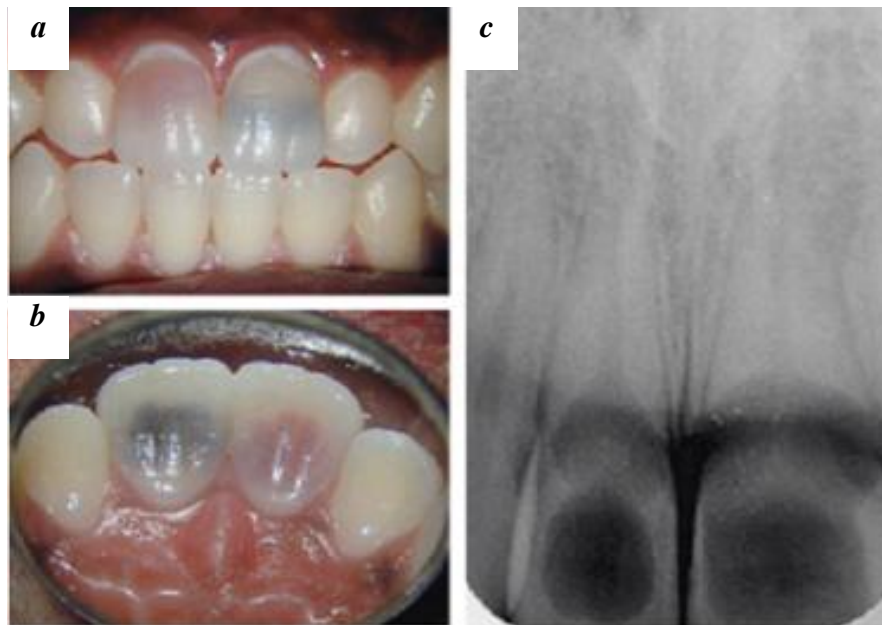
(a) A patient with large internal inflammatory root resorptions in both maxillary central incisors. Tooth #11 has a pink discoloration indicating that the pulp is vital, whereas tooth #21 has a dark discoloration, an indication of pulp necrosis. (b) The teeth seen from the palatal side. Strong discolorations are clearly visible. (c) A radiograph of the teeth reveals wide destruction of dentin and enamel caused by internal inflammatory root resorption. *Courtesy of Dr. M. Ree*
